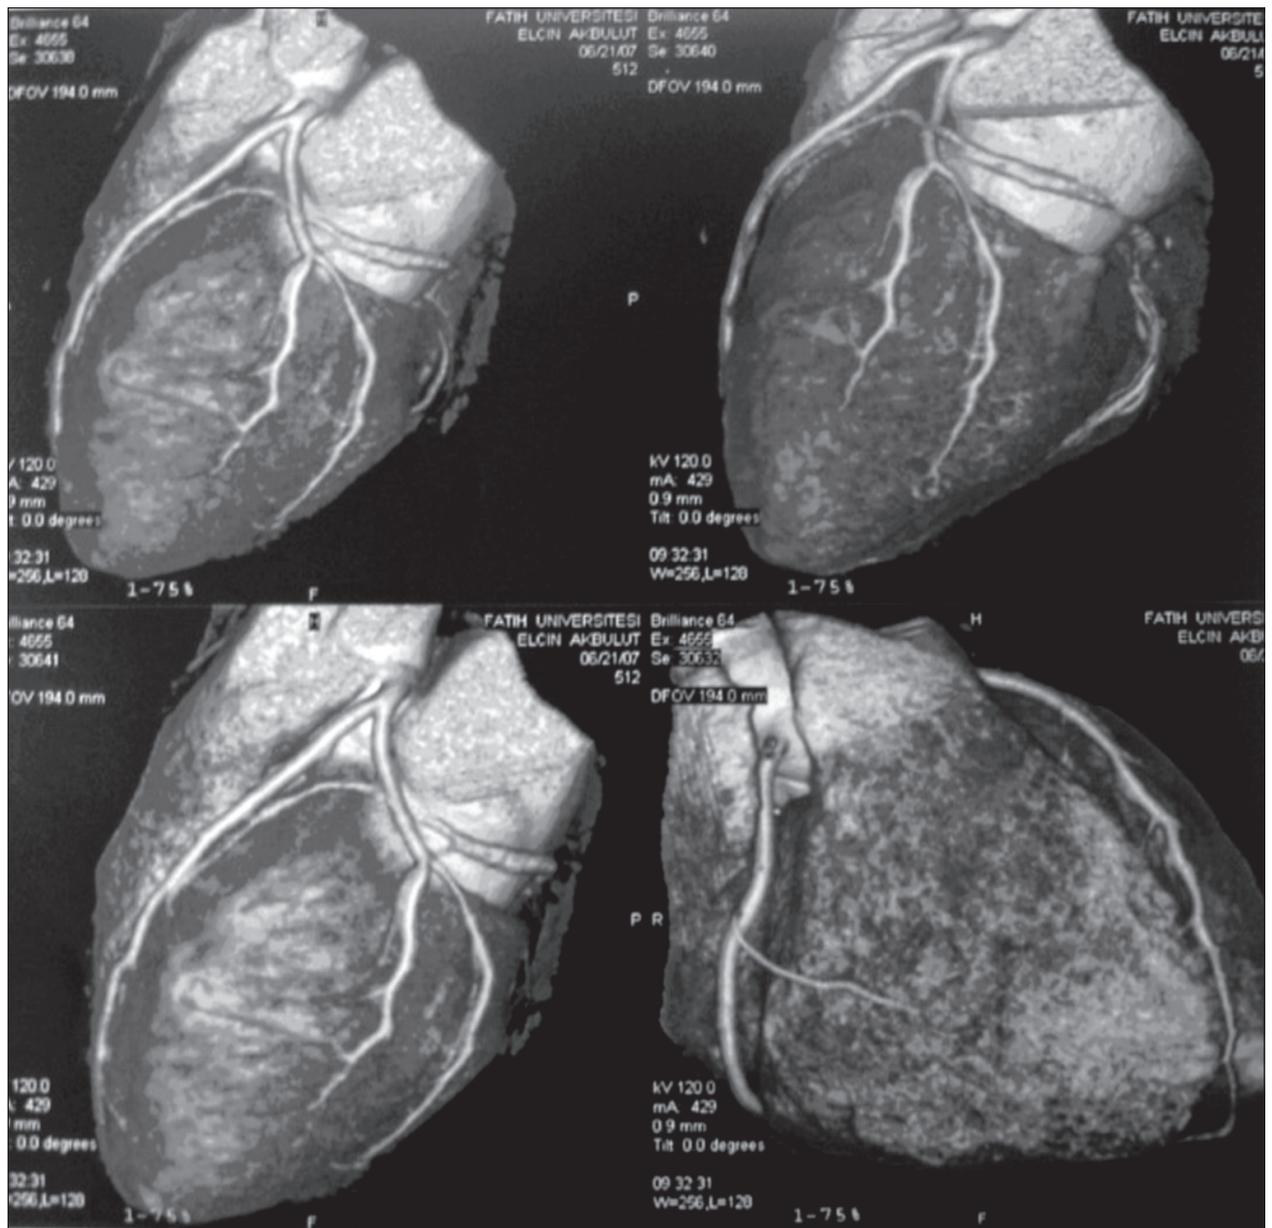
64-slice multislice computed tomography coronary angiography showing normal coronary arteries.
